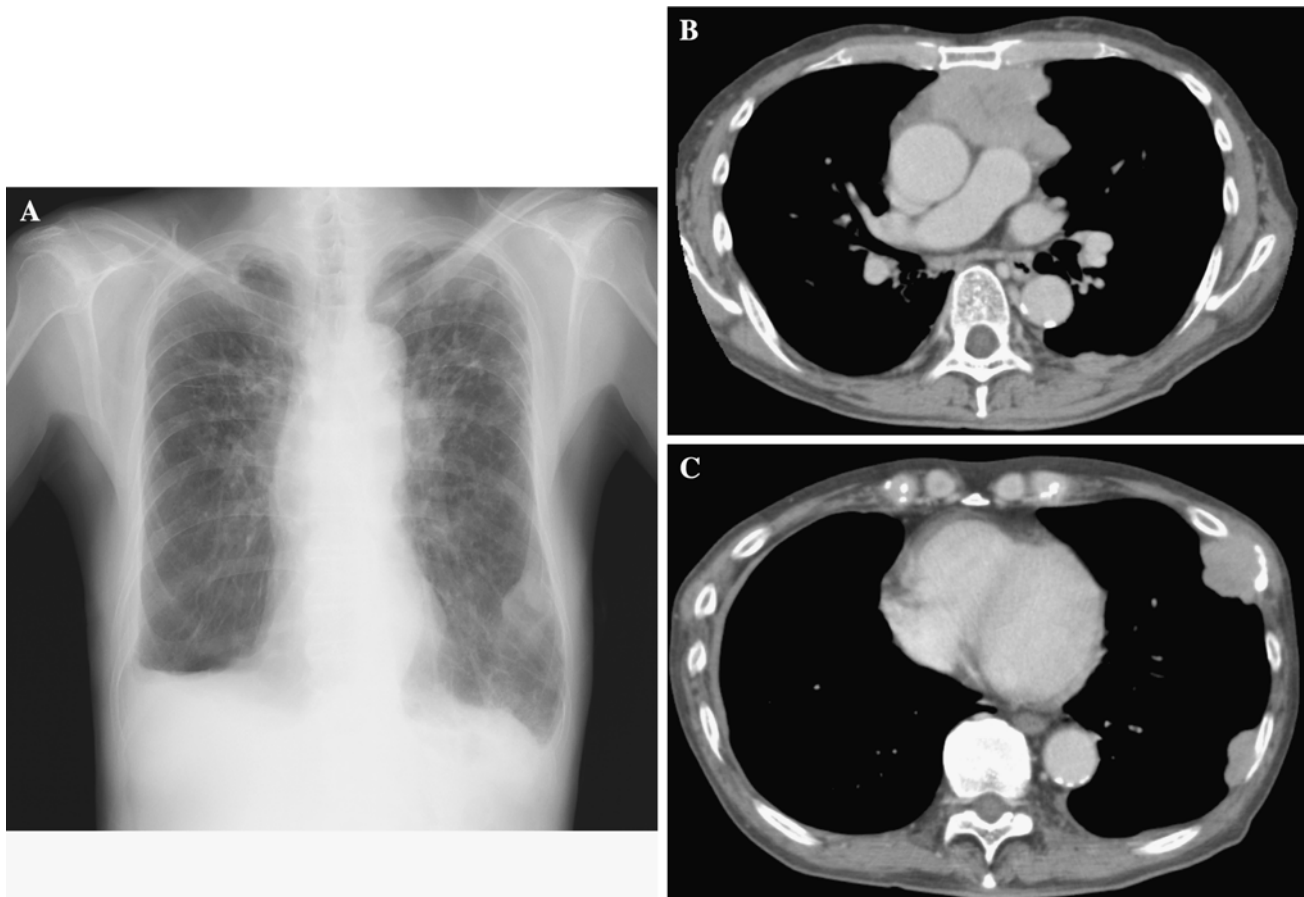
a Chest radiograph on admission shows a mass protruding from the mediastinum into the left hilar region. b, c Enhanced chest CT scans on admission show the mediastinal mass and pleural dissemination
